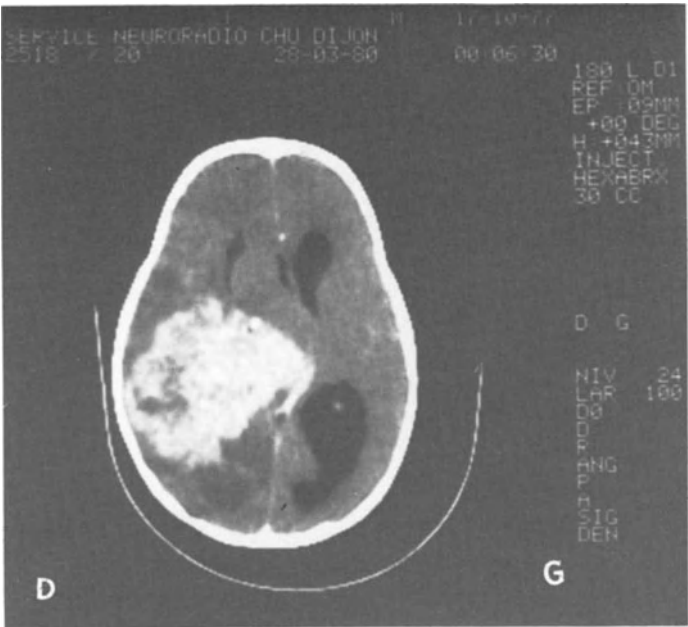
Enhanced CT appearance of a choroid plexus carcinoma with unilateral hydrocephalus
